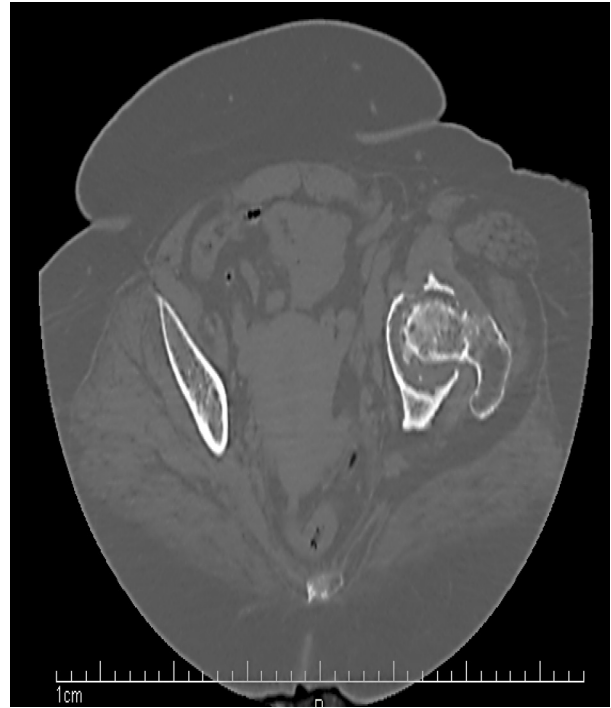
Axial CT scan of the pelvis without contrast: resorption of the right femoral head with advanced degenerative changes
